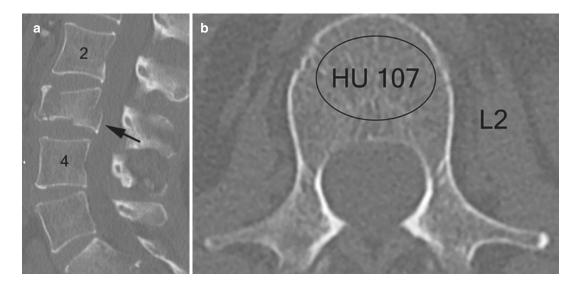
(a) A Sagittal CT of 68 year-old female showing L3 burst fracture following a fall. She has history of steroid use and osteopenia. The arrow indicates retropulsed bone from posterior inferior body of L3. (b) Axial CT at L2 above her fracture. The mean Hounsfield Unit (HU) in the region of interest (Oval) was 107 indicating likely osteoporosis. (c) At 3 months follow-up, she is doing poorly with increasing back and leg pain. Lateral radiograph shows further collapse and increased retropulsion of bone into spinal canal at L3. (d) Sagittal T2 MRI at 3 months confirming retropulsion of bone into spinal canal at L3 (arrow). (e) Lateral radiograph 1 year after minimally invasive corpectomy L3 and reconstruction with expandable cage from L2 to L4 and second-stage posterior pedicle screw instrumentation. The pedicle screws were augmented with bone cement. (f) Anterior posterior radiography one year after surgery
